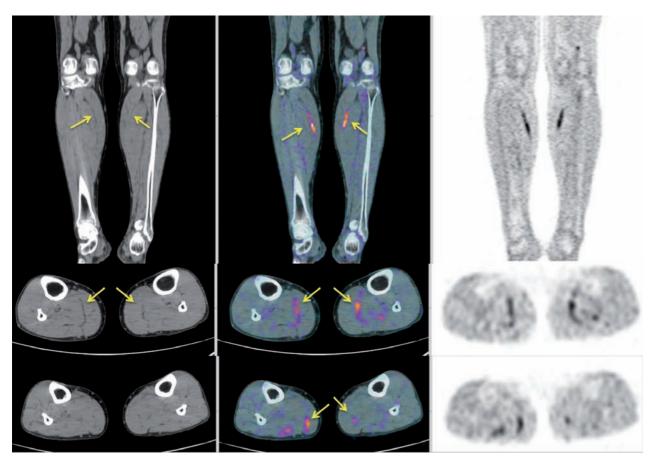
Combined FDG PET/CT images of the lower limbs. PET (right column), fused PET/CT (middle column) and corresponding CT (left column) images of the lower limbs demonstrate linear increased FDG uptake extending along the fascia between the gastrocnemius muscle and the soleus muscle bilaterally (left and middle columns: arrows, right column: no arrows)
